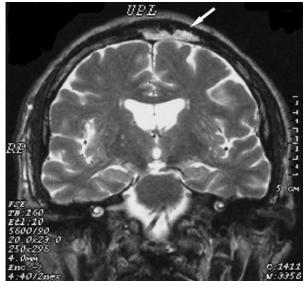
Coronal MRI in T2 sequence demonstrating a hyperintense lesion of the left frontal bone crossing the midline toward the dorsal part of the frontal bone (white arrow).
